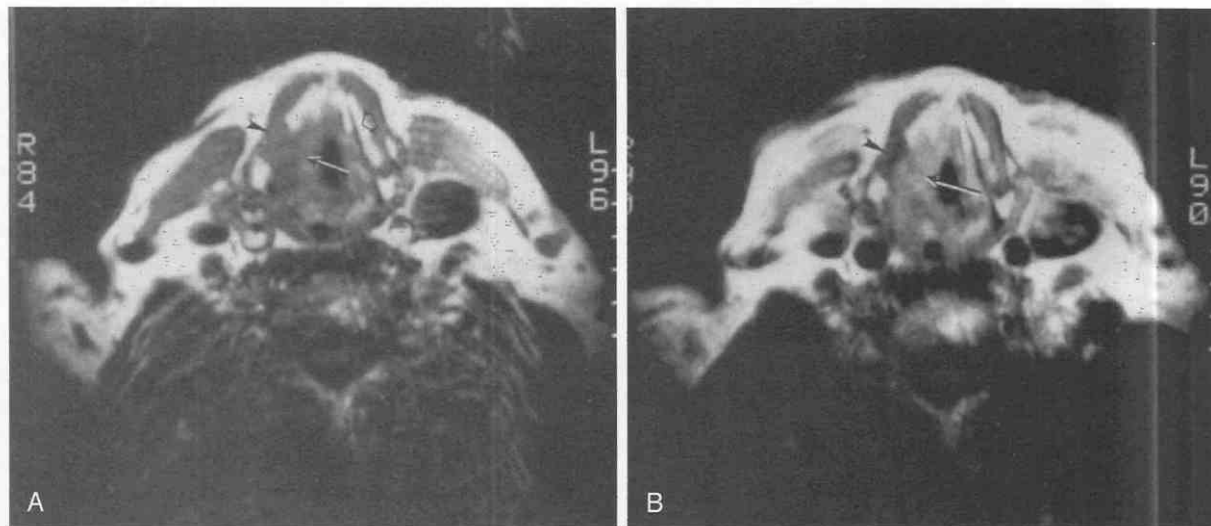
Supraglottic tumor without cartilage invasion. *A*, Short TR, short TE. The tumor (arrow) abuts an area of the cartilage (arrowhead) that has the same signal intensity. On the opposite side, a normal ossified thyroid lamina with bright signal of medullary fat (open arrow) is identified. *B*, Long TR, short TE. The tumor (arrow) is significantly brighter than the nonossified cartilage (arrowhead). (From Curtin HD: MR and CT of the larynx. In Thrall JH [ed]: Current Practice of Radiology, 3rd ed. St. Louis, Mosby-Year Book, 1994.)
